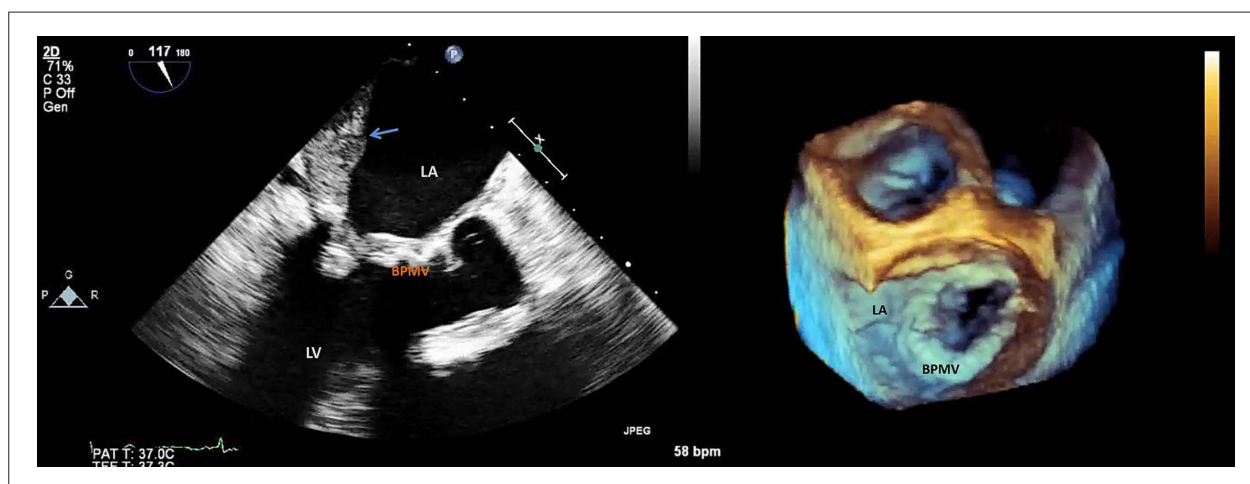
Transesophageal echocardiogram long axis view and 3D zoom on face view of the mitral valve presenting a significant thickening of mitral bioprosthetic cusps due to thrombotic material deposition, leading to severe obstruction of the prosthetic valve and a large mural thrombus covering the left atrial posteroseptal wall (pointed with an arrow). BPMV: Bioprosthetic Mitral Valve; LA: Left Atria; LV: Left Ventricle.
